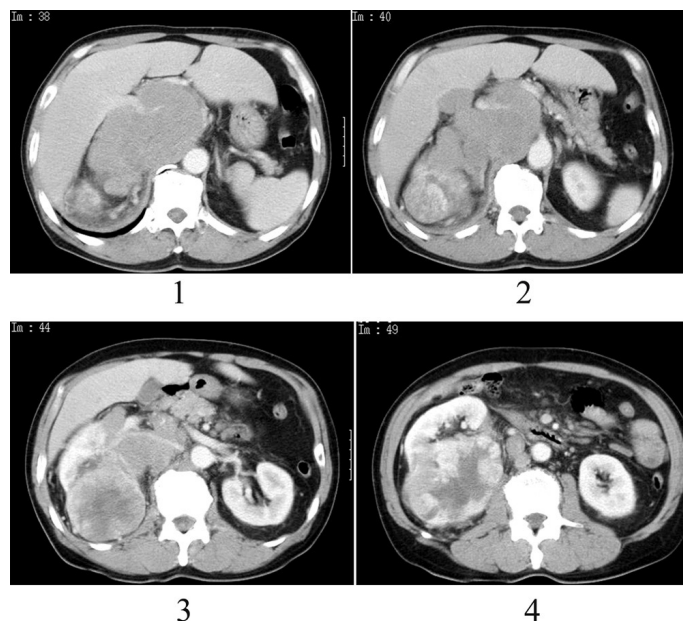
Enhanced CT of the tumors in the right kidney and in the retroperitoneum.
